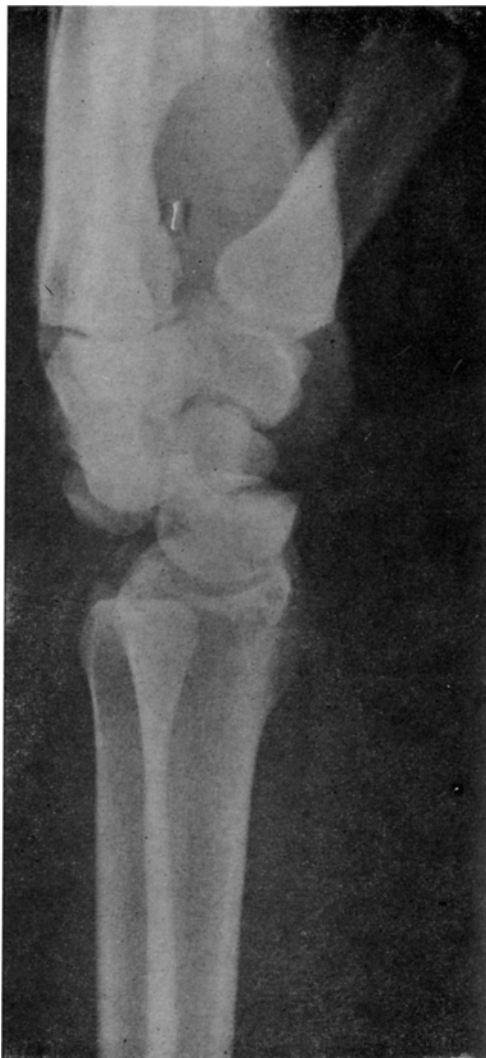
Lateral radiograph showing dorsal trans-scaphoid perilunate dislocation.
